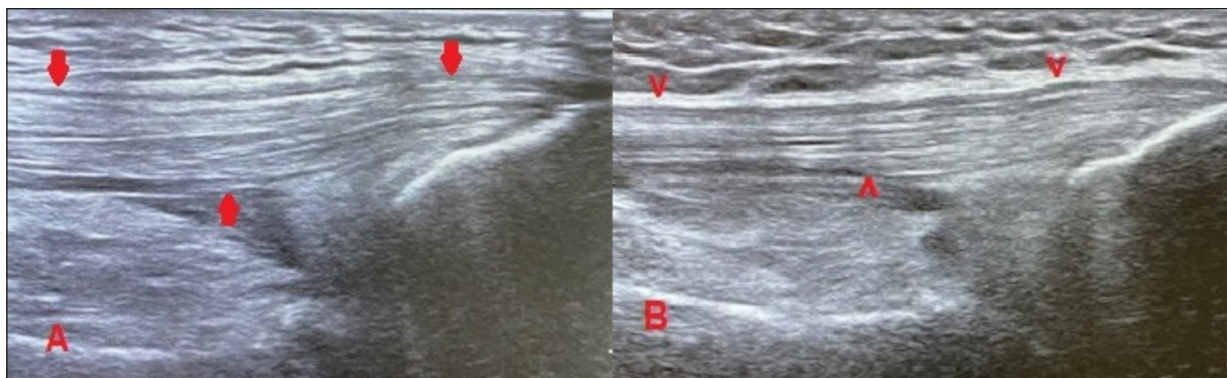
Ultrasonographic images of quadriceps tendon thickness, sonographic view of the longitudinal axis. A, 45-year-old male nondiabetic, quadriceps tendon with a normal thickness (arrows). B, 46-year-old male diabetic, thin quadriceps tendon (arrowheads).
